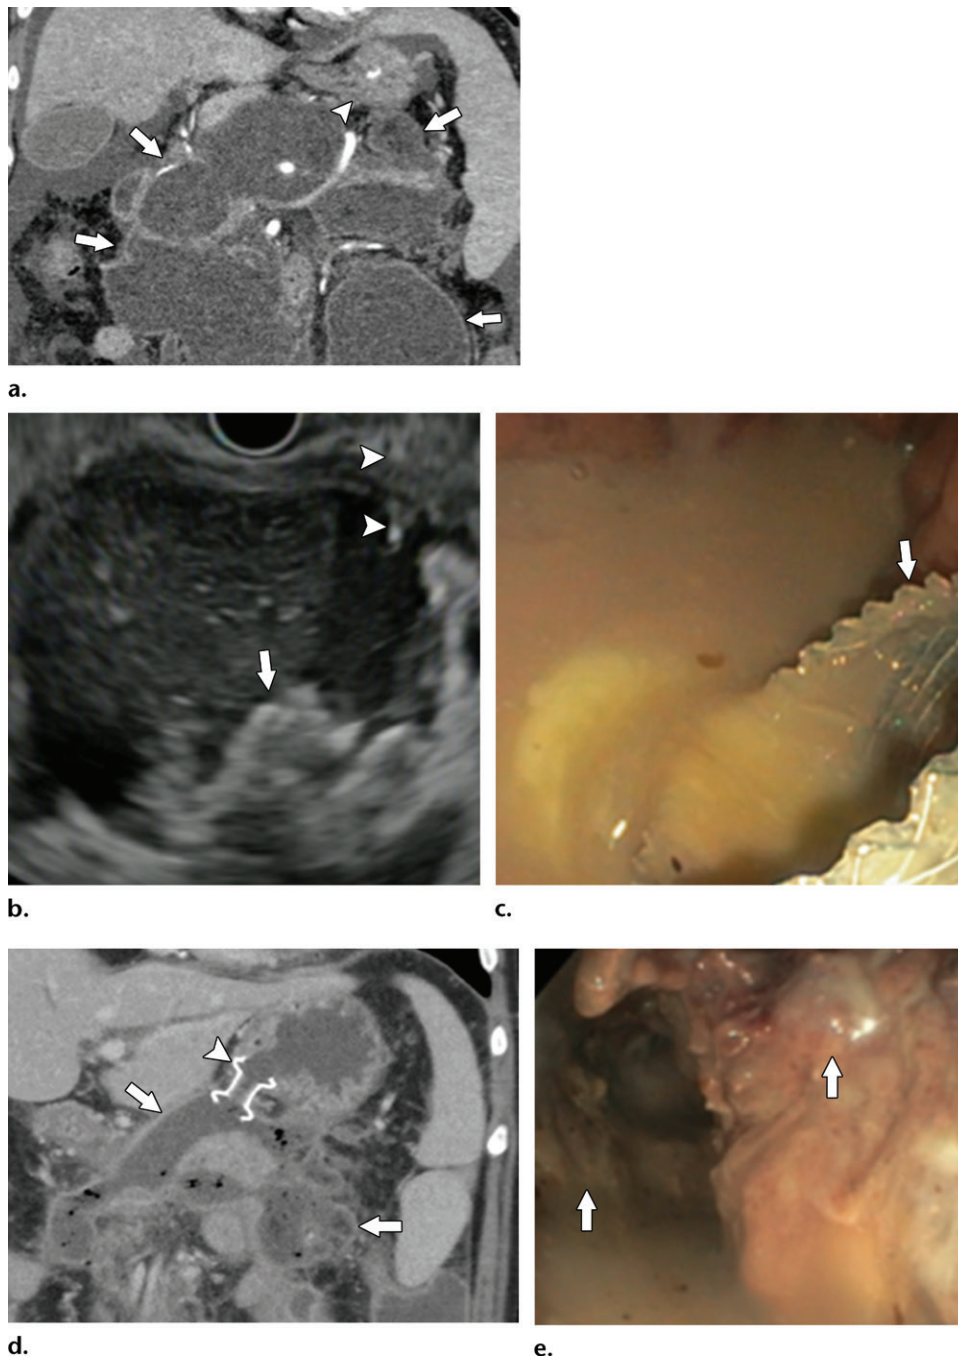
ETD using a lumen-apposing metal stent (LAMS) with subsequent ETN in a 59-year-old man with sepsis and WON. (a) Coronal contrast-enhanced CT image shows a large WON (arrows) in the peripancreatic space and mesentery. Note its proximity to the stomach (arrowhead). (b) Endoscopic US image of the stomach shows heterogeneous fluid and solid debris (arrow) within the WON. Needle access (arrowheads) allows wire passage before balloon dilatation of the tract and placement of the LAMS. (c) Endoscopic image from the stomach shows immediate drainage of purulent fluid into the stomach after the placement of the LAMS (arrow). (d) Coronal contrast-enhanced CT image obtained 5 days later shows a cystogastrostomy LAMS (arrowhead) in the appropriate position and smaller but persistent WON (arrows). (e) Endoscopic image obtained from a repeat endoscopy with the endoscope driven through the stent shows a view into the collection that allows for the assessment and débridement of the necrotic material (arrows), which appears adherent to the wall of the collection.
